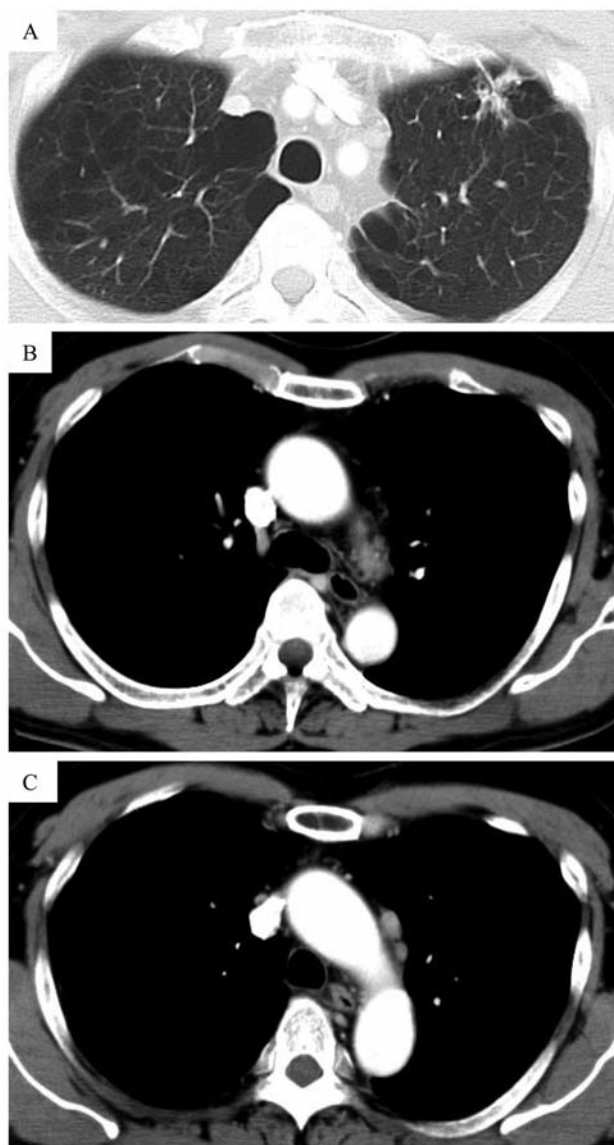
A: Case 1: Case without recurrence: Chest computed tomography (CT) showing a tumor in the upper left lobe. B and C: Chest CT shows mediastinal lymph node swelling. Left upper lobectomy and systematic lymphadenectomy were performed. The pathological findings showed papillary carcinoma (moderately differentiated adenocarcinoma), with ly3, v1, n2 (#4:1/5, #5:1/3, #6:4/5, #7:0/2, #10:0/3, #11:0/1, #12u:0/2, #12l:0/1). The pathological stage was judged to be T1N2M0 stage IIIA. EGFR was judged to be wild-type. Adjuvant therapy was administered. The patient has remained alive for five years without evidence of recurrence.
